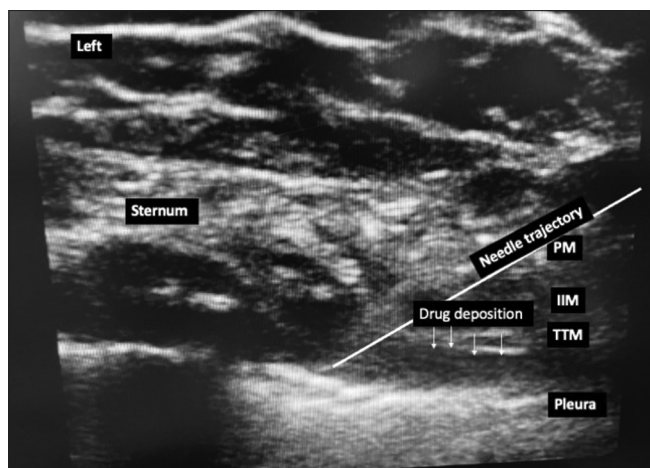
The ultrasound image showing an in-plane technique for Tuohy's needle placement between the inner intercostal and transverse thoracic muscles, depositing the ropivacaine between transverse abdominis muscle and transversalis fascia on the left side (IIM: Internal intercostal muscle; PM: Pectoralis major; TTM: Transversus thoracic muscle)
